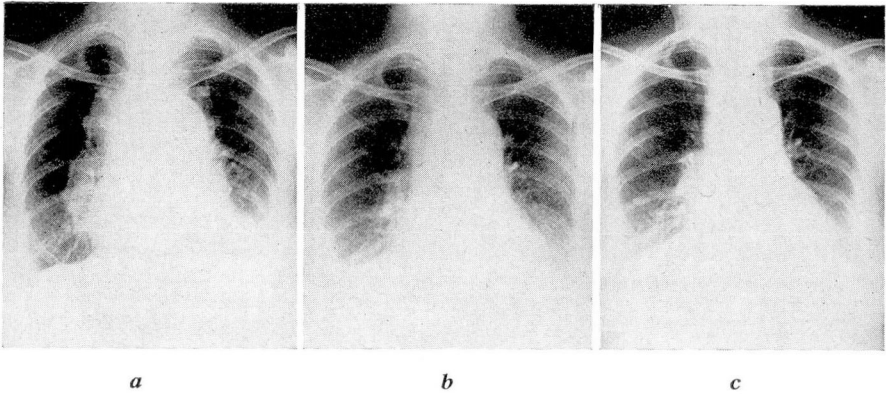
Case 11. Roentgenograms of the chest.
